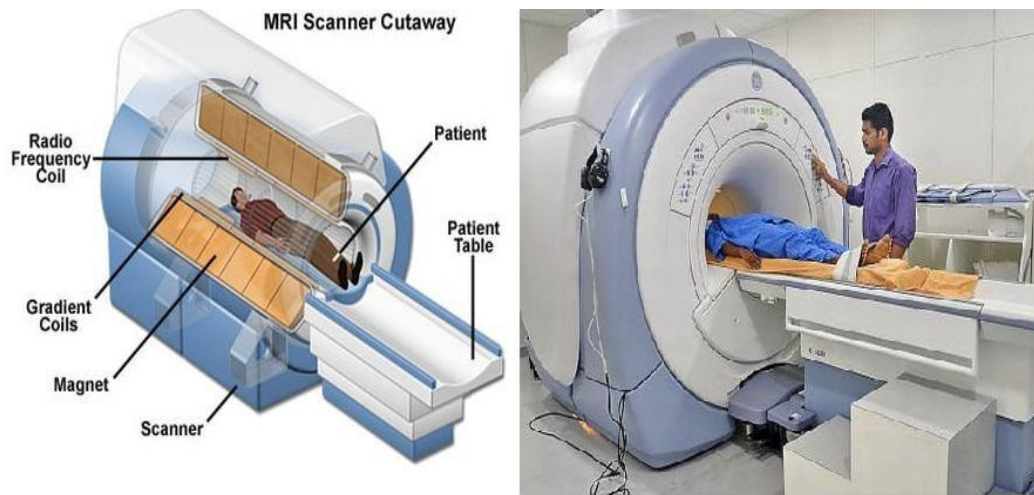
2.2. Cutaway MRI Scanner [Al-Tamimi, M. S. H., & Sulong, G. et.al. (2014)]
